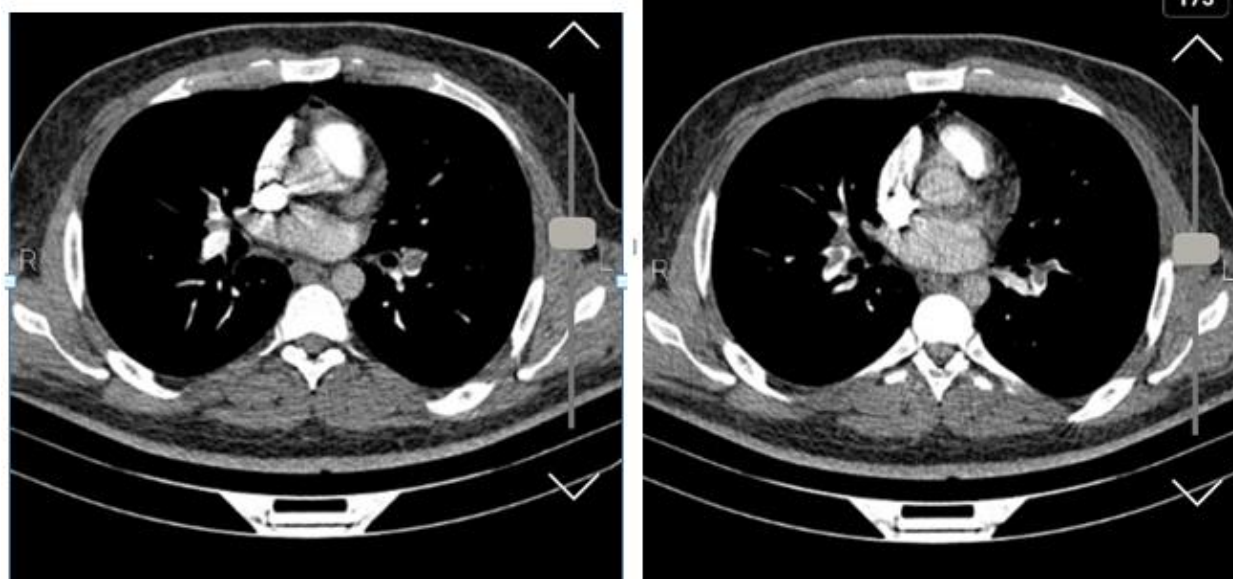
Parenchymal infarction in spiral computed tomography of the chest.
